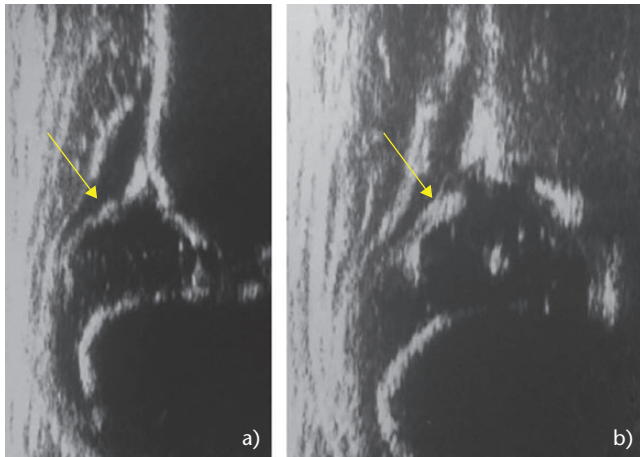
(A) An ultrasound image of a type III hip in a two-week-old male; (B) the same hip (normalized) at the end of treatment (age five months). The yellow arrows indicate the position of the labrum on top of the femoral head. It is clearly visible that there is an increase in echogenicity and dimensions after treatment in Figure 3B.
